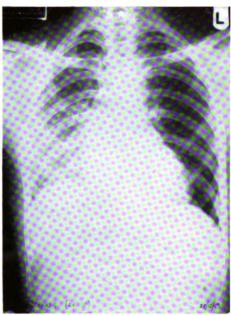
Forced expiration radiograph of Case 3, showing "trapping" on the left. Increased transradiancy is present on this side.
